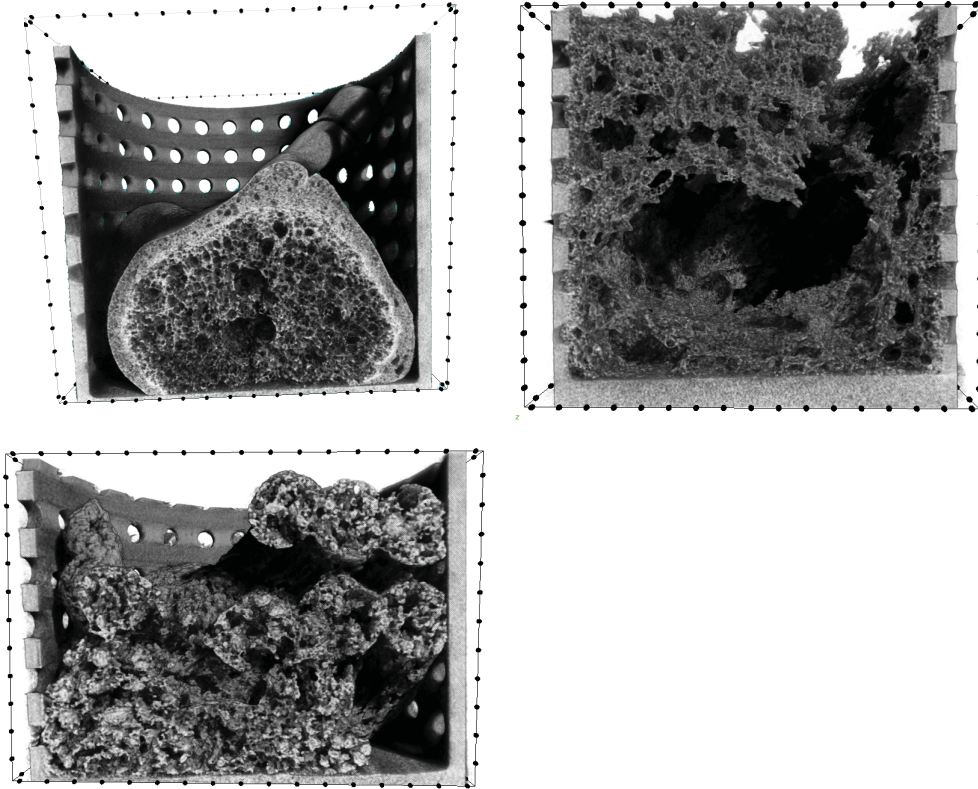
X-ray μ -CT images of DF prepared using MSB with M21D (top left), ISM (top right) and 50%MTL (bottom left) as filler.
